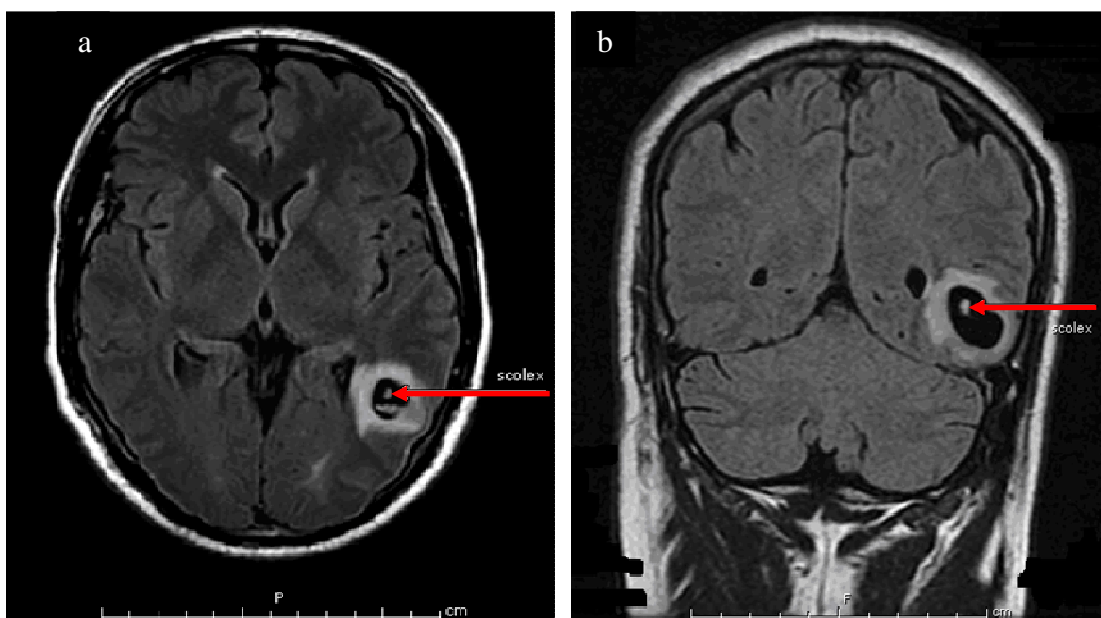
MRI on day of admission. Red arrows note the scolex visible in the cyst.
